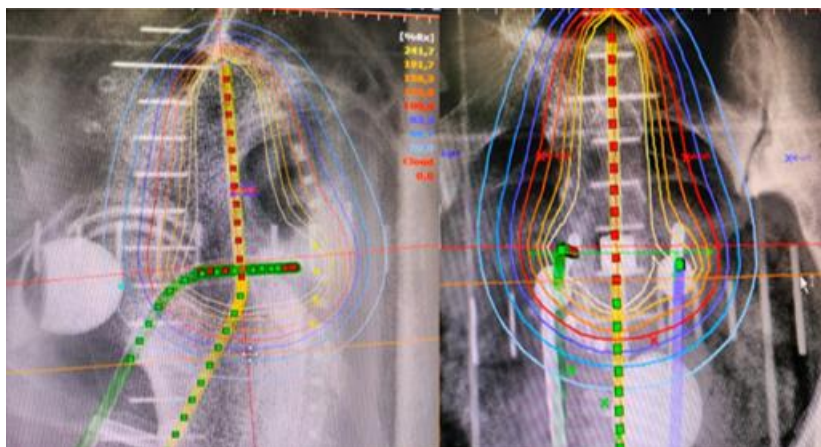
Orthogonal Radiographs showing Dwell positions and Isodose Distribution
